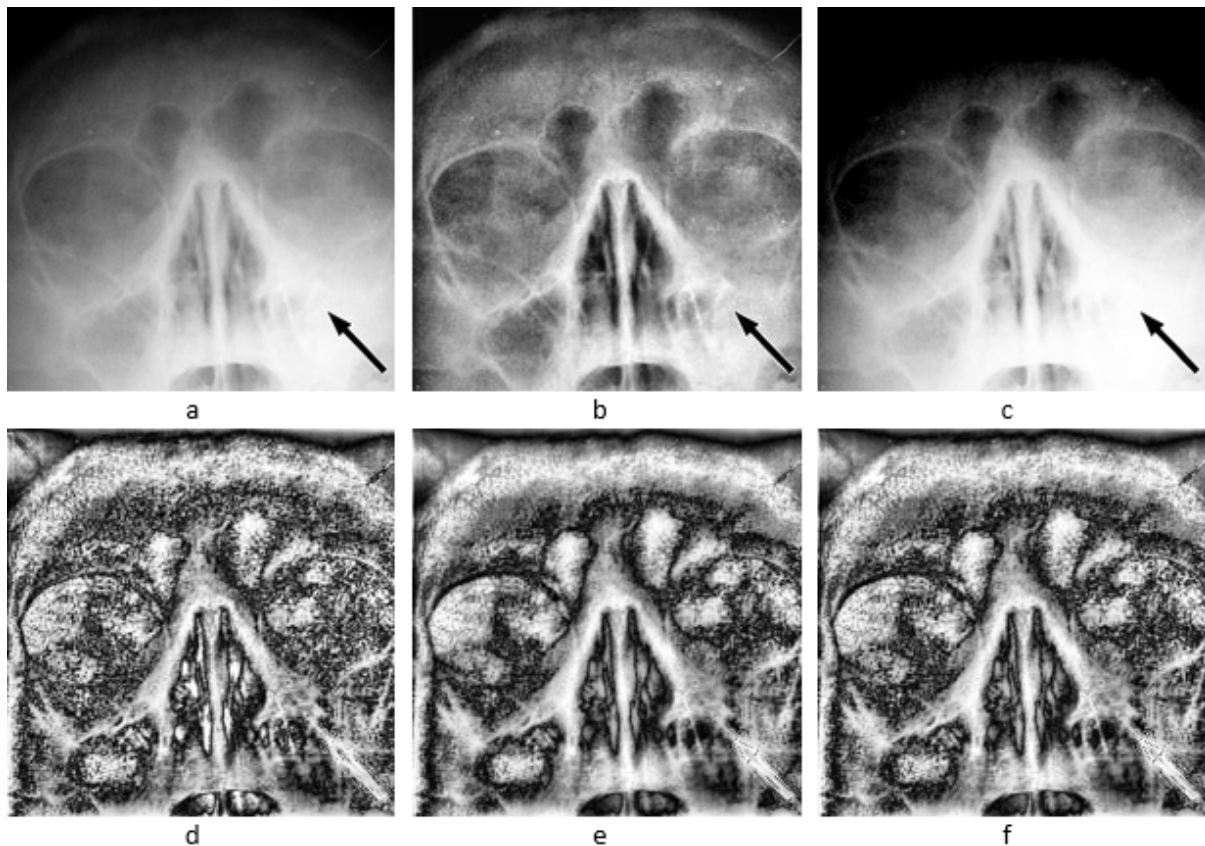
X-ray image of a human face: a – original image (266x272); b – adaptive histogram equalization; c – intensification operator; proposed algorithm using: d – $r_1 = 0.95, r_2 = 0.7$; e – $r_1 = 1.2, r_2 = 0.7$; f – automatic calculation of r_1, r_2 using formulas (14) and (15), respectively.
